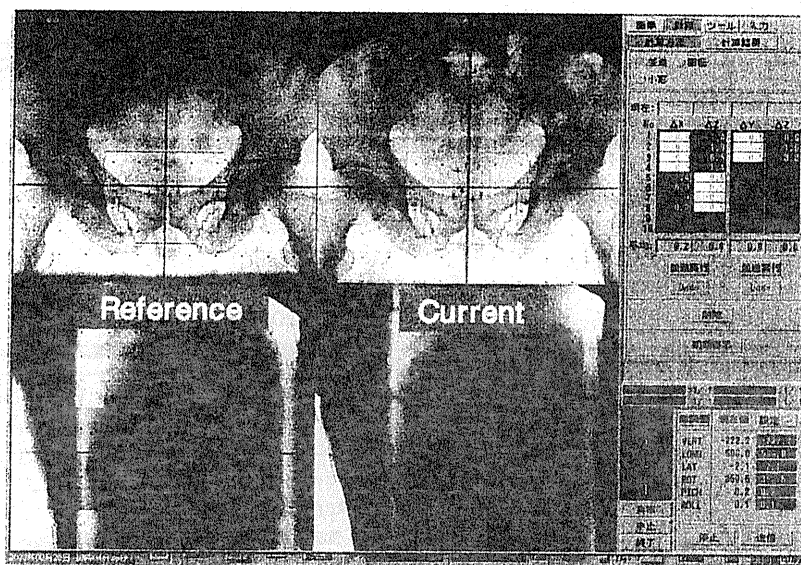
Online positioning using an orthogonal X-ray TV system
